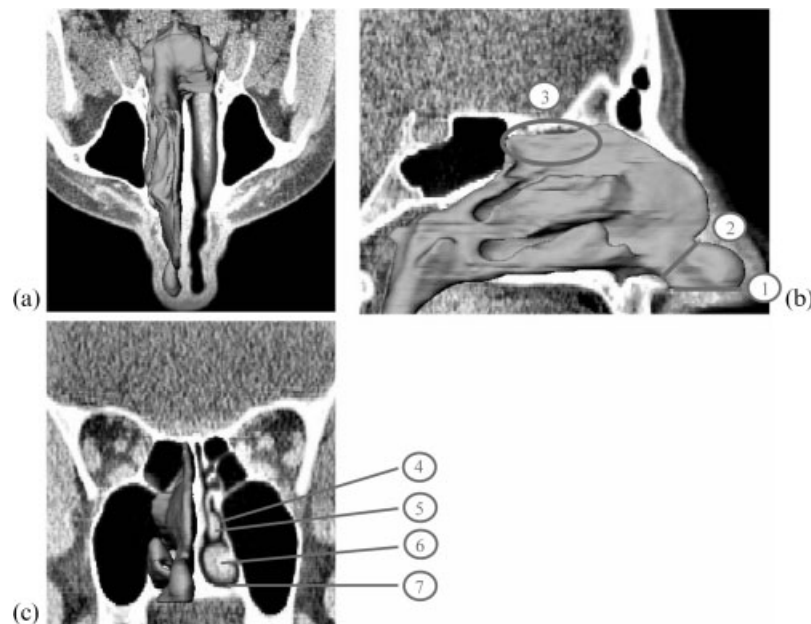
Unilateral reconstruction of nasal airway, performed in AmiraTM. (a) Single axial CT slice with the reconstructed right nasal airway superimposed. (b) Sagittal CT slice with reconstructed surface superimposed, where the identified features are as follows: 1, nostril; 2, nasal valve; 3, olfactory region. (c) Coronal CT slice with superimposed airway, where the identified features are as follows: 4, middle meatus; 5, middle turbinate; 6, inferior or lower turbinate; 7, inferior meatus
